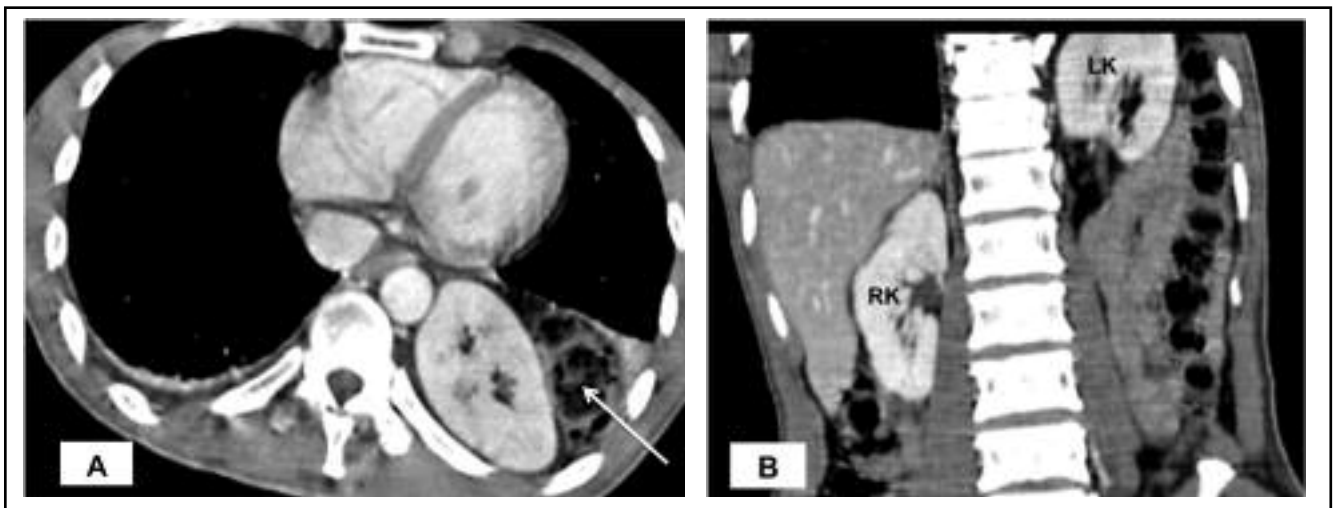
Computed tomography of the abdomen. (A) Axial contrast-enhanced scan showed the left kidney and part of the bowel (arrow) within the thoracic cavity, in this image at the level of T10. (B) Coronal reformatted image showed higher location of left kidney (LK) compared to normal position of right kidney (RK).
